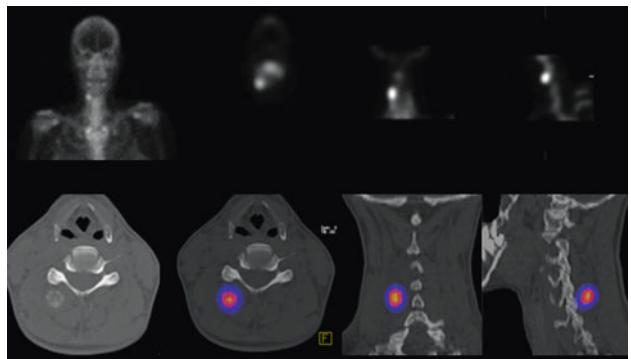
Above: scintigraphy with increased uptake on the right paraspinal region. Below: CT (on the left) and combined information from CT and scintigraphy (hybrid imaging).
